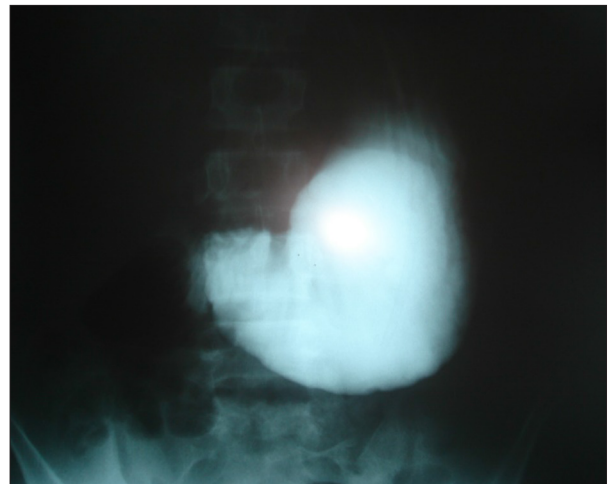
The appearance of the dilated stomach extending to the pelvic region in UGI radiography.
